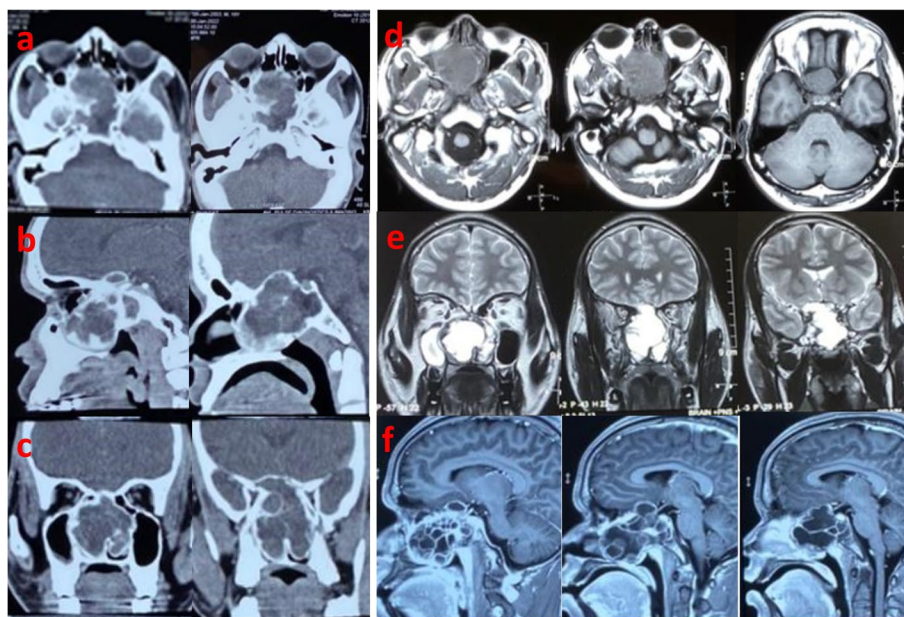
Preoperative contrast CT (a, b, c) and contrast MRI (d, e, f) shows an expansile lytic cystic lesion with peripheral rim enhancement in the region of the posterior ethmoidal and sphenoid sinus
